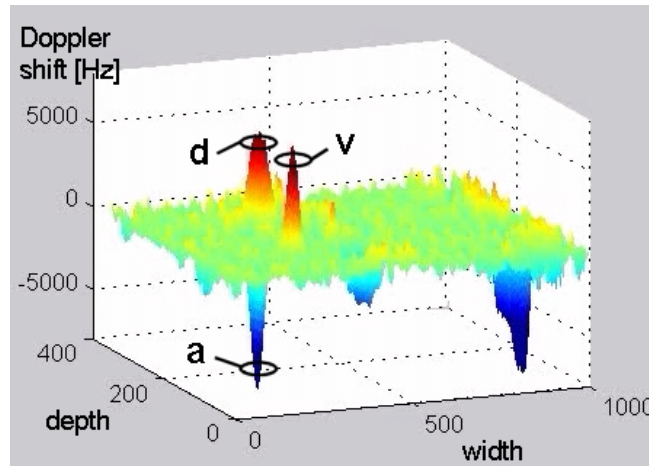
(1.01 MB) Movie of dynamic blood flow within the human retina, *in vivo*, corresponding to the movie presented in Fig. 3. Image width and depth are mapped onto the XY-plane, with Doppler signal [Hz] displayed on the Z-axis. Width and depth are denoted in pixels. a: artery; v: vein; d: choroidal vessel.
